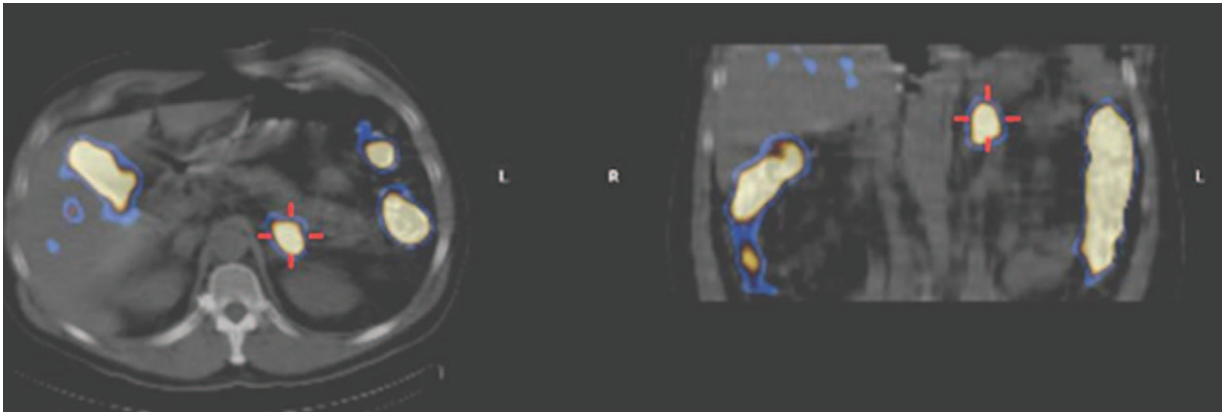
SPECT-CT. Intense focal radiotracer uptake in the left adrenal adenoma.
